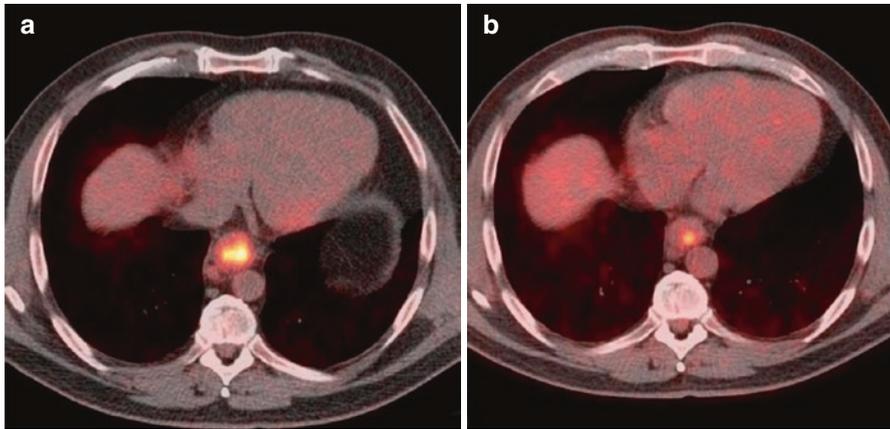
Axial fused PET/CT images before (a) and after (b) therapy show the marked improvement of FDG activity of the tumor, most consistent with good therapy response
